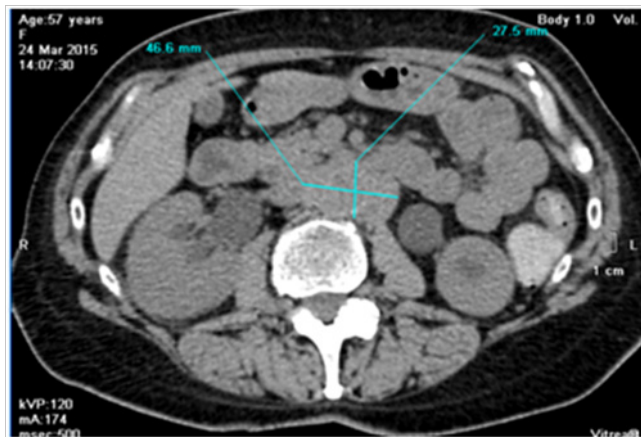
CT scan, showing retroperitoneal mass.
